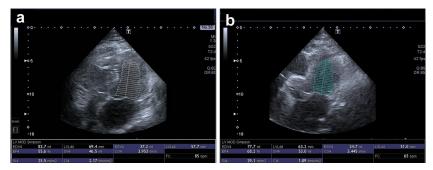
Apical four-chamber views with left ventricle volume measurements for (a) tele-echocardiography and (b) reference echocardiography.
